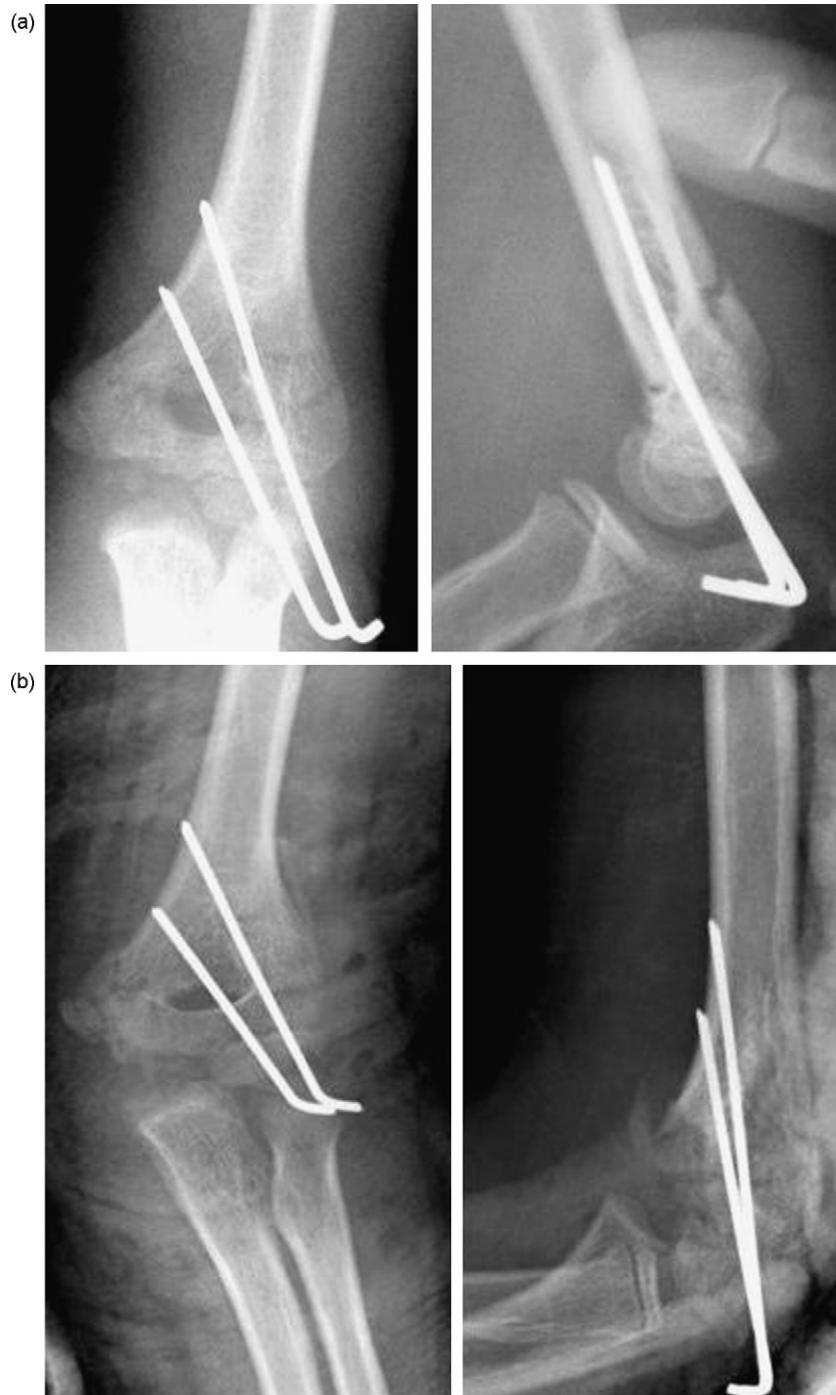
(a) Anteroposterior and lateral views of the left elbow showing type III supracondylar humeral fracture reduced perfectly and fixed with two lateral pins. (b) Early postoperative redisplacement, more evident in lateral radiograph, due to persistent instability at the fracture site.
